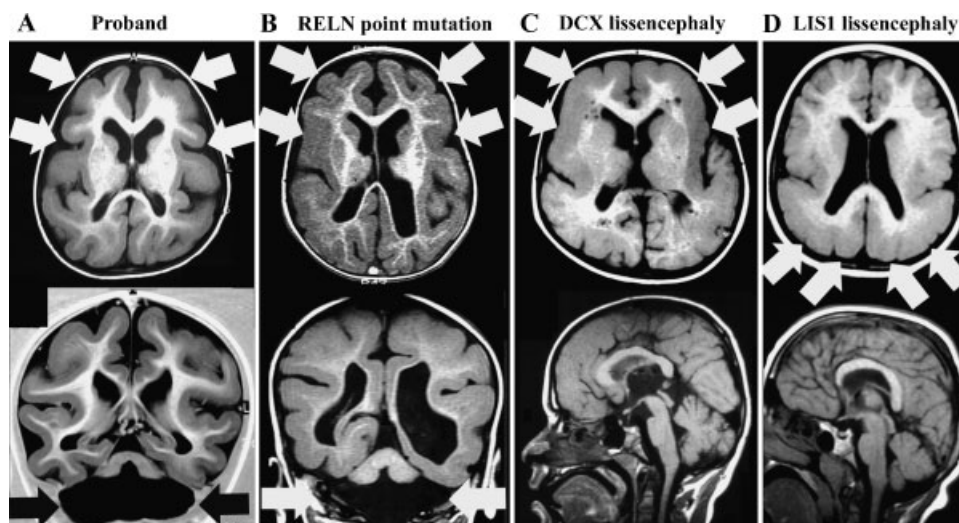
Brain magnetic resonance imaging of *RELN*-associated lissencephaly with cerebellar hypoplasia compared to classical lissencephaly. T1-weighted axial (top row) and coronal (bottom row) brain magnetic resonance images from the proband with homozygous chromosome 7 inversion (A) and an individual with a known *RELN* point mutation (B) demonstrate the typical features of LCH, including bilateral pachygyria (white arrows) and profound hypoplasia of the cerebellar vermis and hemispheres (black arrows in A and white arrows in B). Comparison T1-weighted axial (top row) and sagittal (bottom row) images from patients with classical lissencephaly due to *DCX* mutation (C) and *LIS1* mutation (D) demonstrate the differing anterior–posterior gradients of pachygyria in these malformations (white arrows), as well as the relative preservation of cerebellar size compared to LCH. (LIS1 images courtesy of A. James Barkovich, M.D.)
